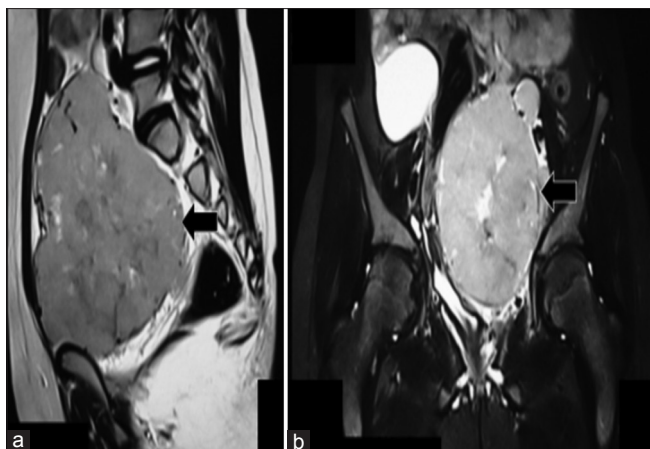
Magnetic resonance imaging (a - sagittal view, b - coronal view) demonstrated a large pelvic mass (arrows in a and b). The left sided ovary was not distinctly identified. The uterus and urinary bladder were displaced and compressed by the mass
